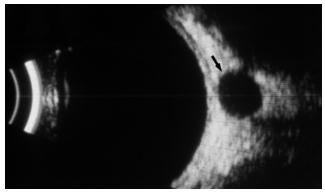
Image showing ultrasonography of the orbit in a patient with an ipsilateral dural CCF. Note the large round void (*arrow*) representing a cross-section of an enlarged SOV.
